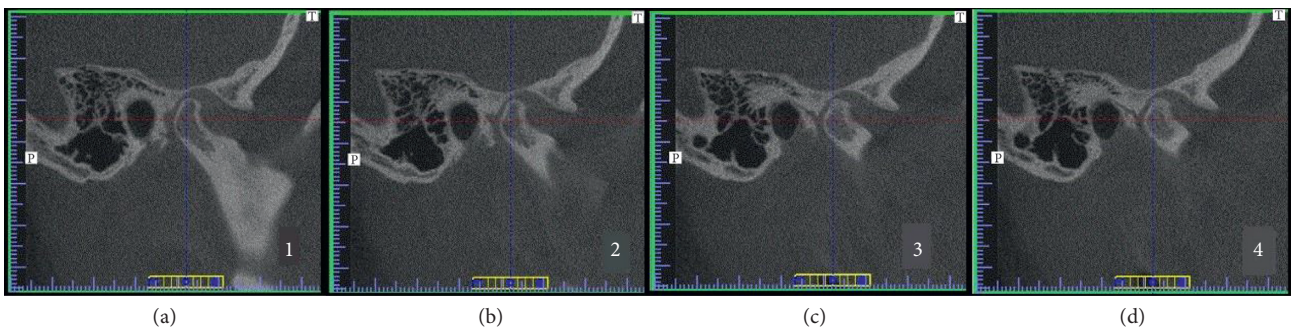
Verification of reproducibility of analyses. (a-d) CBCT images of various patients from the analyzed cohort.
